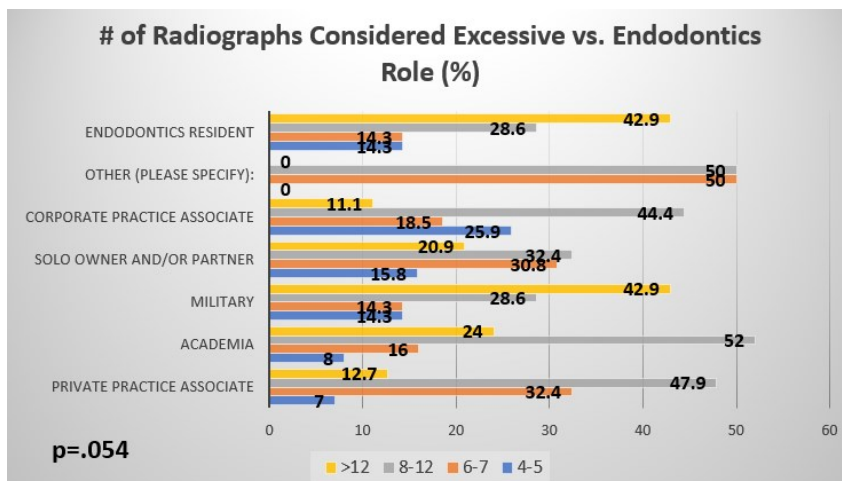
Chi-square data comparing the quantity of radiographs considered excessive and the endodontics role.
